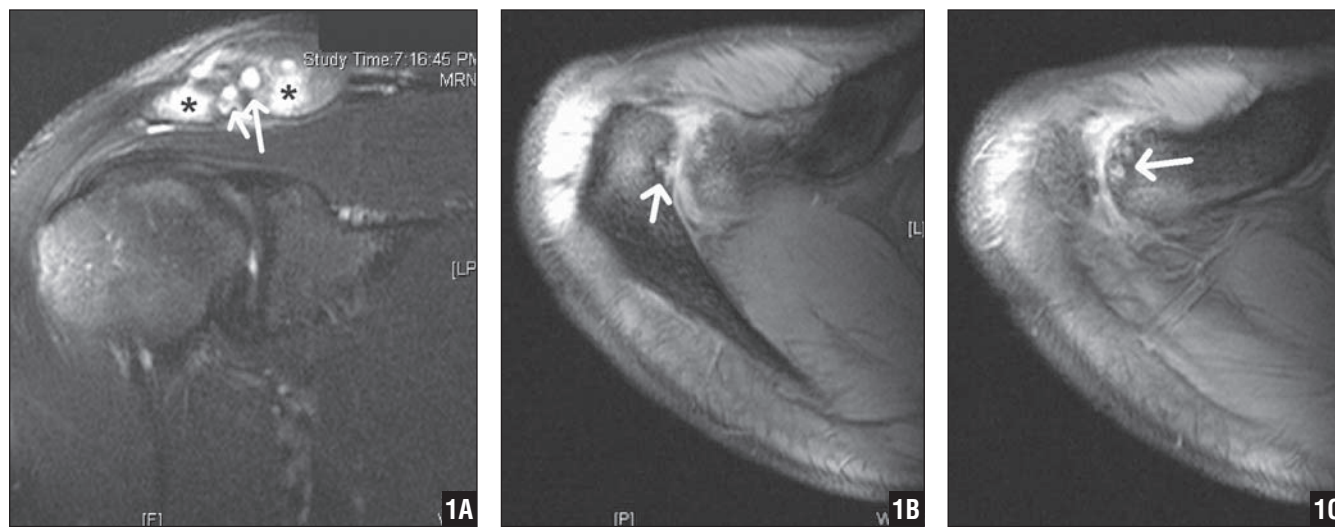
Coronal (A) and axial (B, C) T2-weighted MRI images demonstrating cystic erosions (white arrows) and edema (black stars) of the distal clavicle and medial acromion. Also note overall enlargement and increased fluid content of joint.
